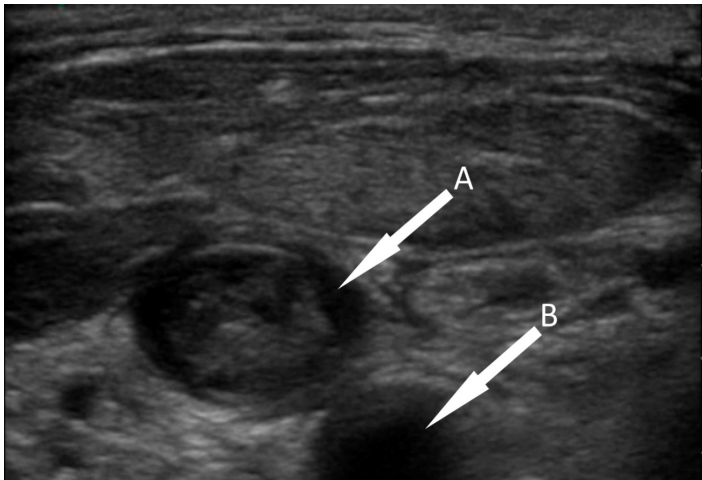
Point-of-care ultrasound of the right internal jugular vein (A) showing echogenic material in the lumen adjacent to the common carotid artery (B).
